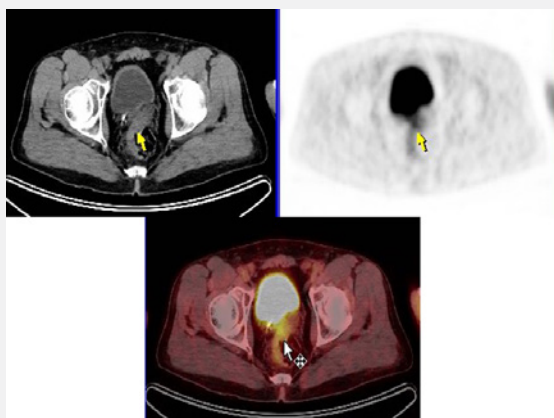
PET/CT images reveals tumor recurrence at the right seminal vesicectomy region.
